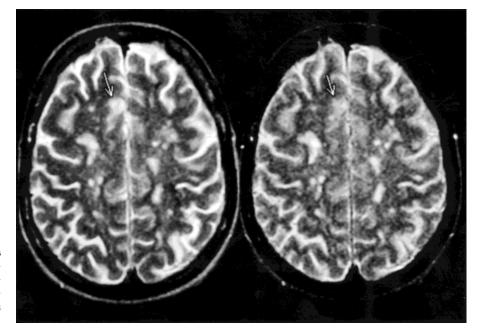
Brain transverse images of T2-weighted FSE (left) and T2-weighted CSE (right) sequences demonstrating better CNR between lesions (arrows) and white matter on the FSE sequence.
